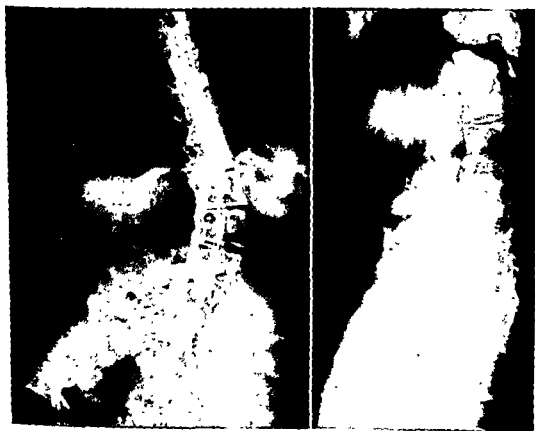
(Left) Anteroposterior and (right) lateral roentgenograms taken preoperatively.
